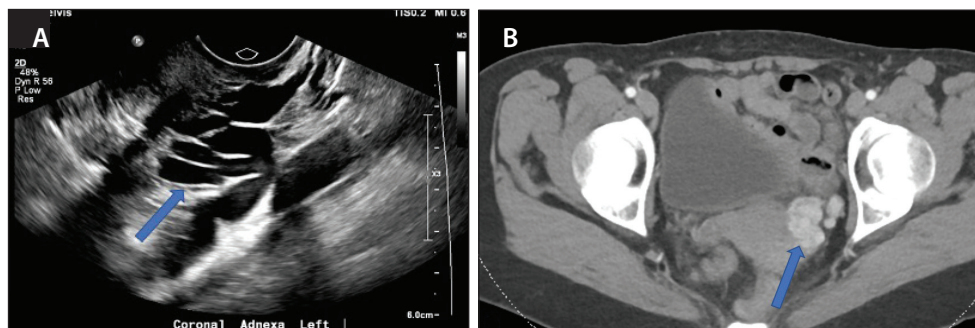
Ultrasound (A) and CT (B) images demonstrate left adnexal and pelvic varices (arrow) measuring up to 7 mm in diameter.
